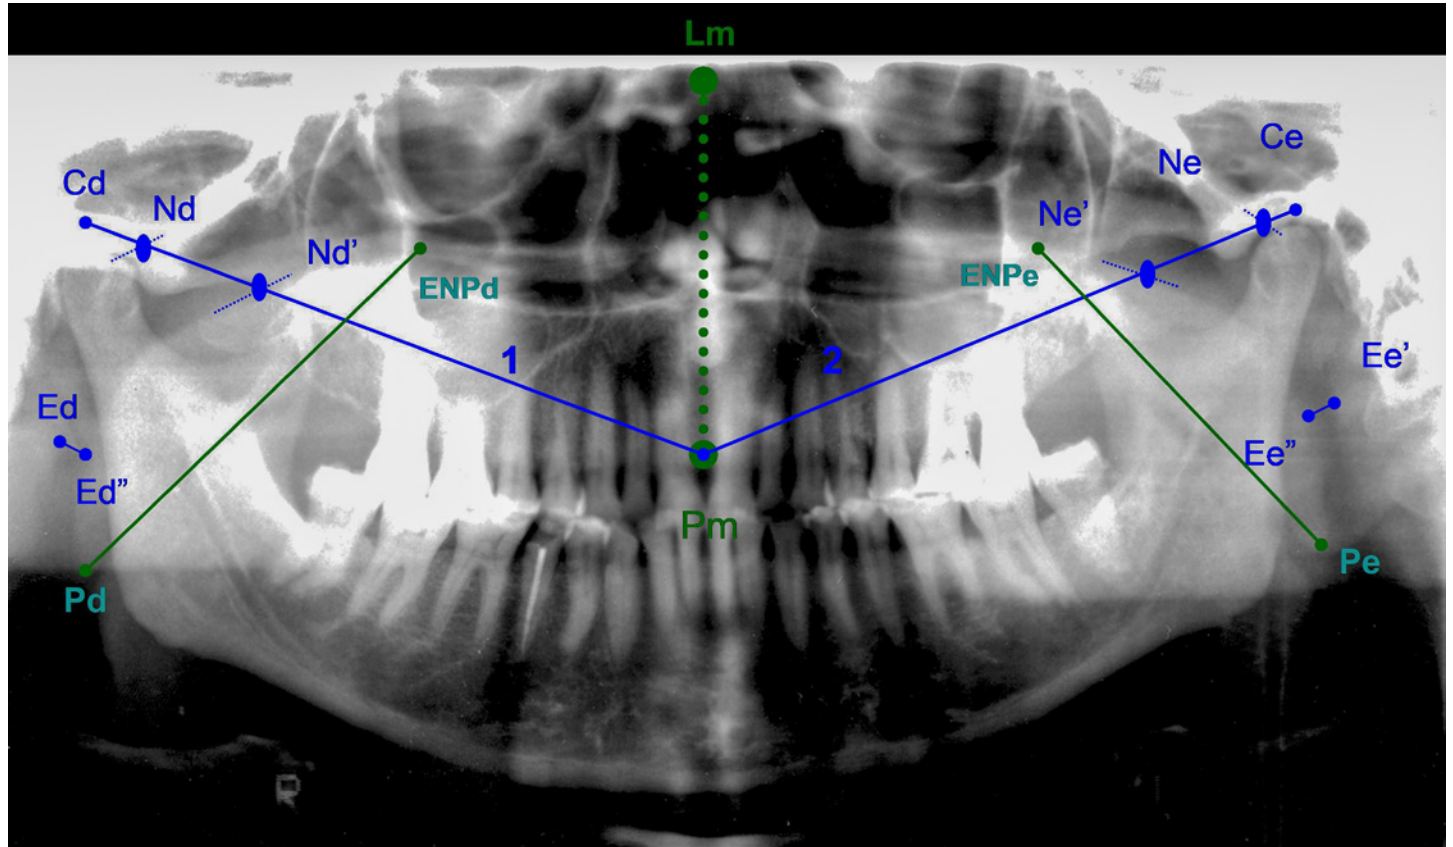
Radiograph tracing with the reference points and the linear measurements
